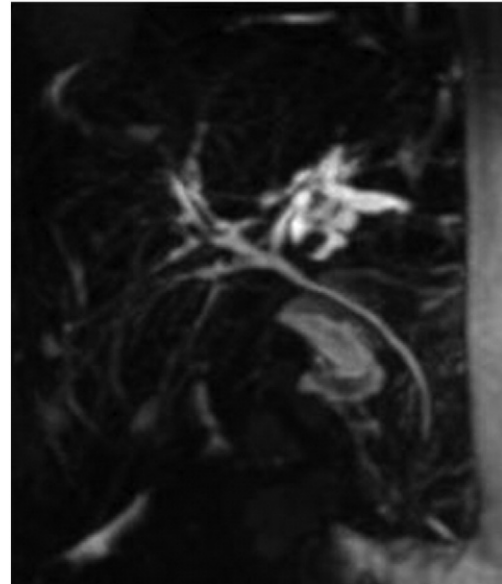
A 3 year-old child, homozygous F508del detected by neonatal CF screening, had normal liver tests and no hepatomegaly. However, screening ultrasound and this subsequent MR cholangiogram revealed significant left intrahepatic bile ductal dilation.
